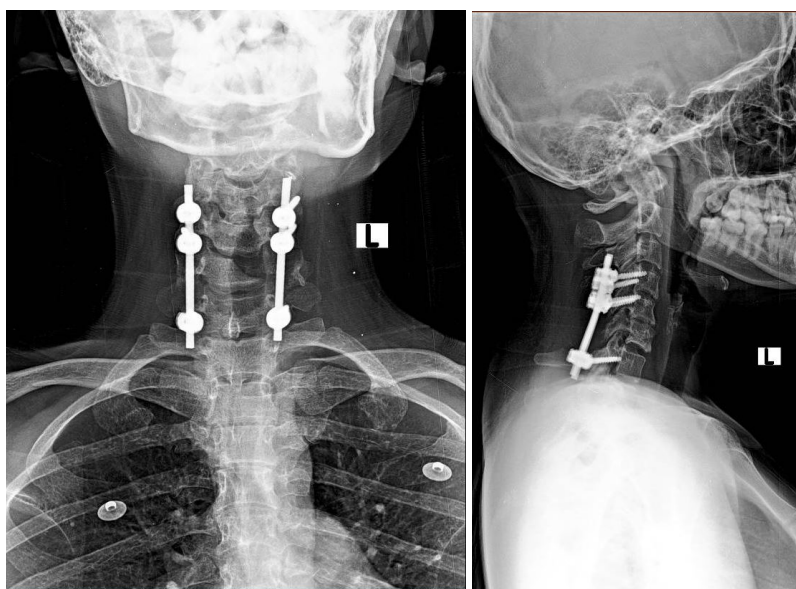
Post operation cervical AP-Lateral plain radiograph
